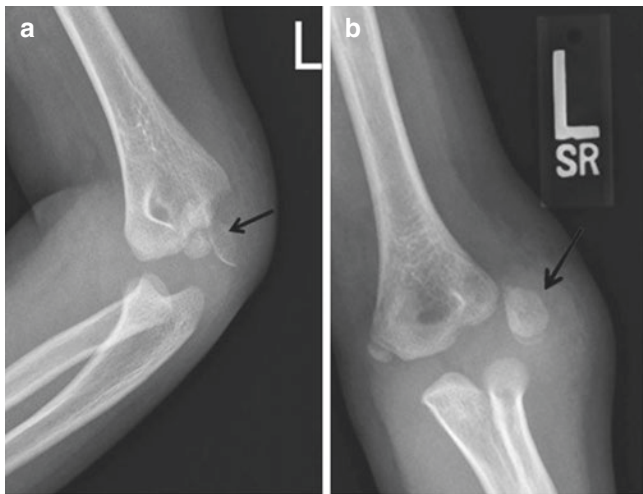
Lateral condyle fracture. A 4-year-old boy fell on an outstretched hand and had elbow pain and swelling. Radiographs (a, b) show a lateral condyle fracture (arrow)
